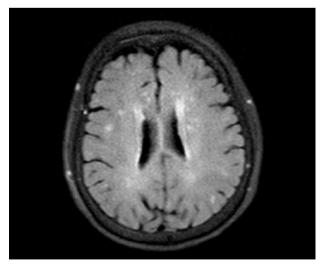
Brain diffusion magnetic resonance image showing a tiny diffusion-restricted lesion in the left frontal white matter. Multiple tiny high signal intensities in both cerebral white matter.
